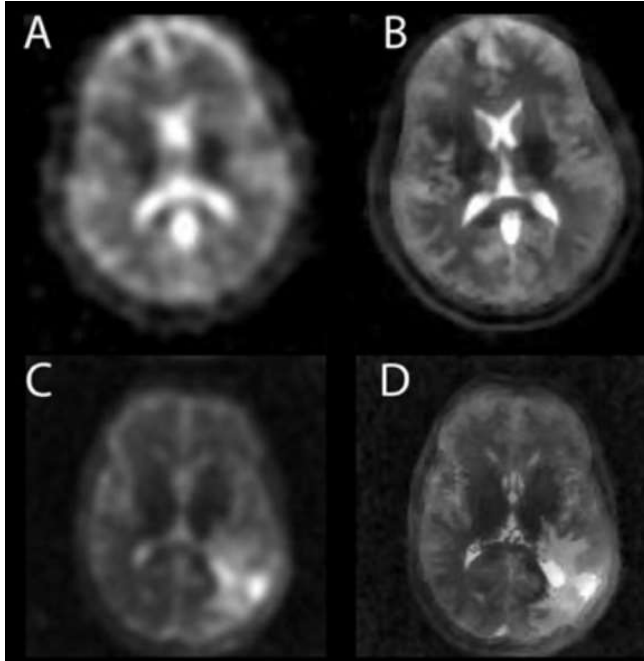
Deblurring  $^{23}\text{Na}$ -MRI with iterative Bowsher reconstruction (IBR). (A) native  $^{23}\text{Na}$ -MRI of a healthy volunteer can be significantly sharpened to (B) using two-point  $T_2$  estimation and anatomic priors. Similarly (C) and (D) demonstrate the benefit of IBR deblurring in a glioma patient, allowing clearer intracranial resolution.
